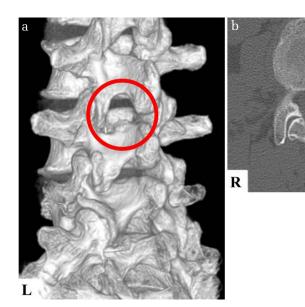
Postoperative 3D CT (a) and CT on axial (b).
